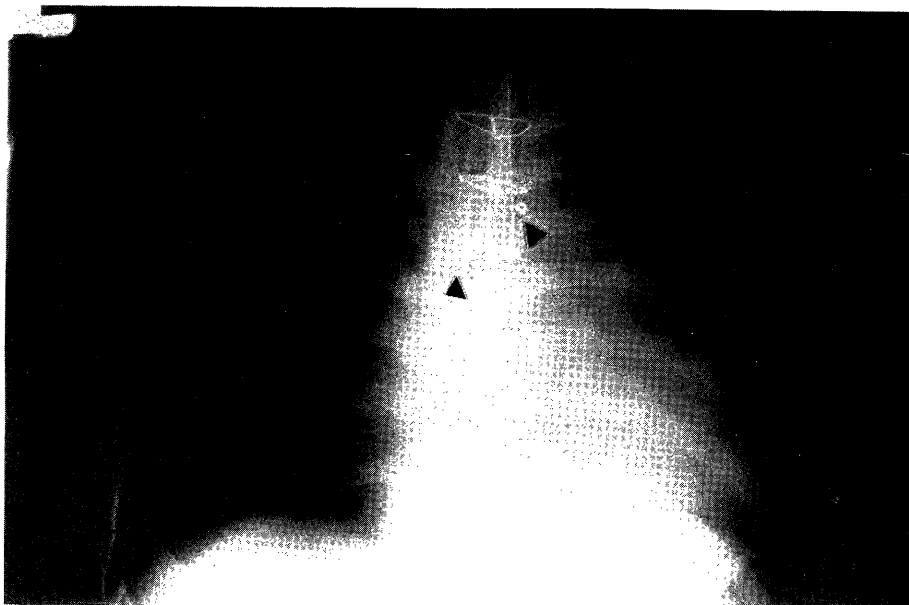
Chest roentgenogram without congestive heart failure after two times embolizations. Arrow points to spring embolus.
